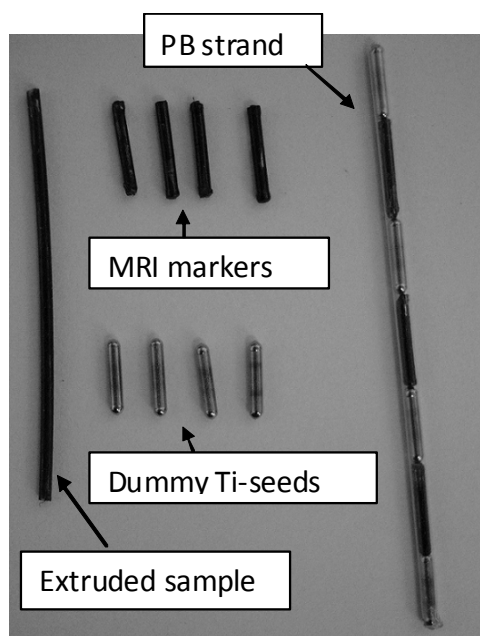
Fabricated PMMA/SWCNTs tubes, dummy Ti-seeds, MRI markers and MRI visible prostate brachytherapy strand.
